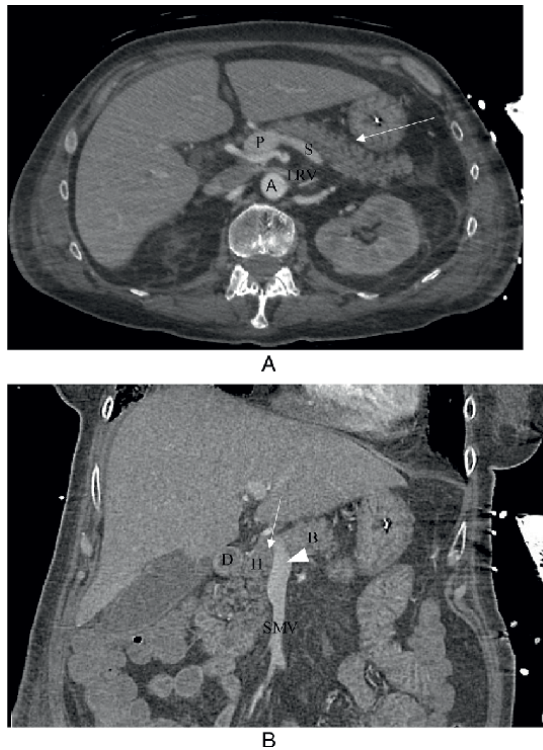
A. CT scan, transverse section of a 52-year-old woman. This is a portal phase. The body and tail of the pancreas (arrow) are behind the stomach. It is visible the portal vein (P) at the confluence with the splenic vein (S). Further back, the aorta (A) and the relationship with the left renal vein, which normally runs on an anteaortic plane. B. CT scan, coronal section, same patient. Here are visible the head of the pancreas (H), the body (B), and the neck (arrow) right where the superior mesenteric vein continues into the portal vein (arrowhead). The horizontal part of the duodenum is visible (D).
